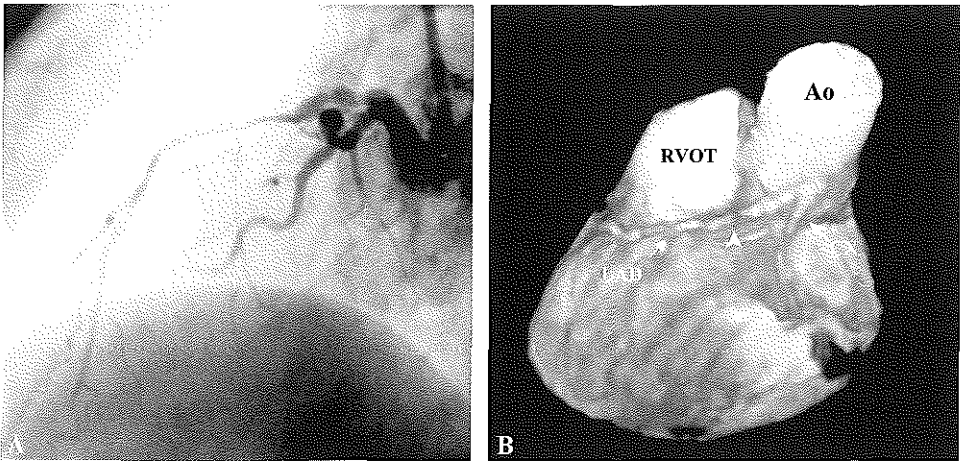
Example of a significant stenosis (arrow head) in the left anterior descending coronary artery (LAD). (A) Conventional coronary angiogram. (B) Magnetic resonance imaging. Ao, aorta; LM, left main; LV, left ventricle; RVOT, right ventricular outflow tract.
